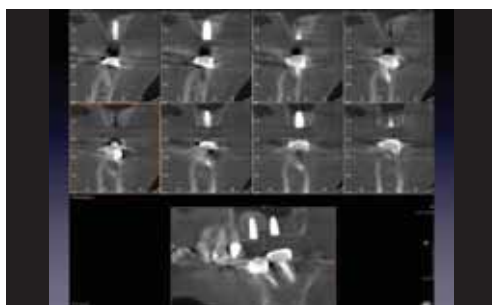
CT scan after implant placement.
